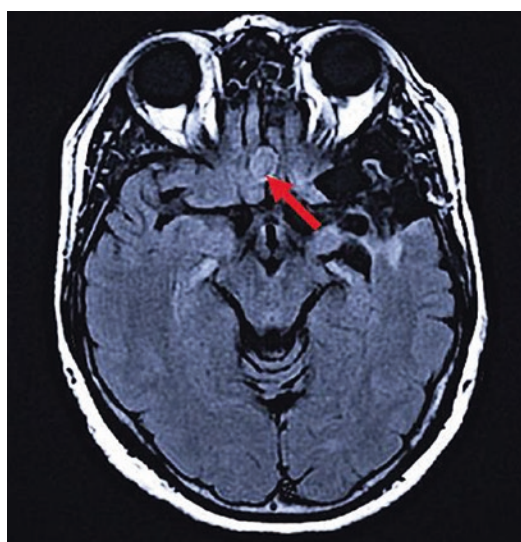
T1 axial MRI scan, demonstrating anatomic approximation of lesion relative to frontal lobes
